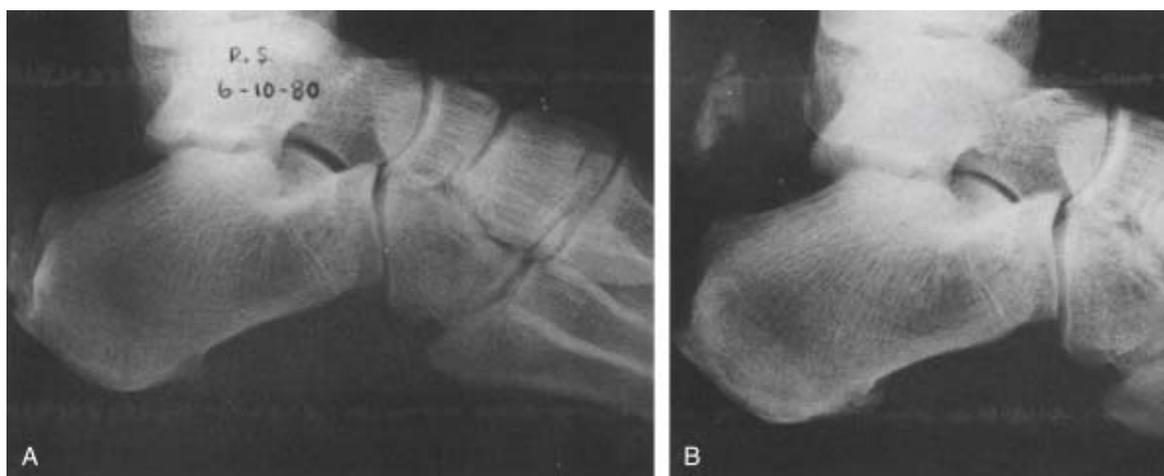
10 Lateral radiographs of a 56-year-old patient with calcification of the Achilles tendon. The radiograph on the left (A) was obtained when the patient was evaluated for plantar fasciitis. Three years later (B), the Achilles tendon was avulsed from the calcaneus.
